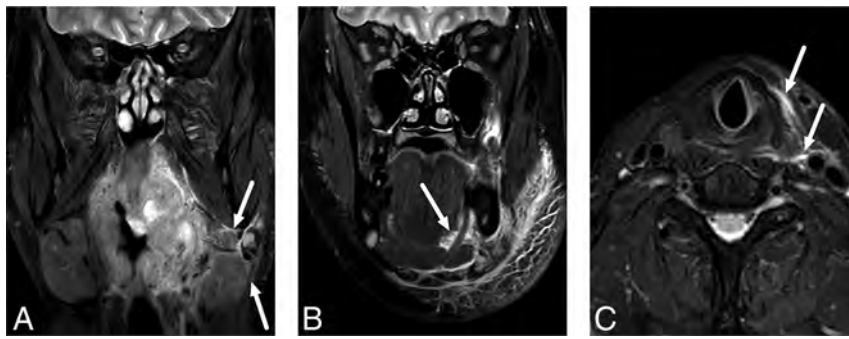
Examples of SMS (A), SLS (B), and VS (C) edema patterns on fat-suppressed T2-weighted Dixon images. Arrows indicate edema.
